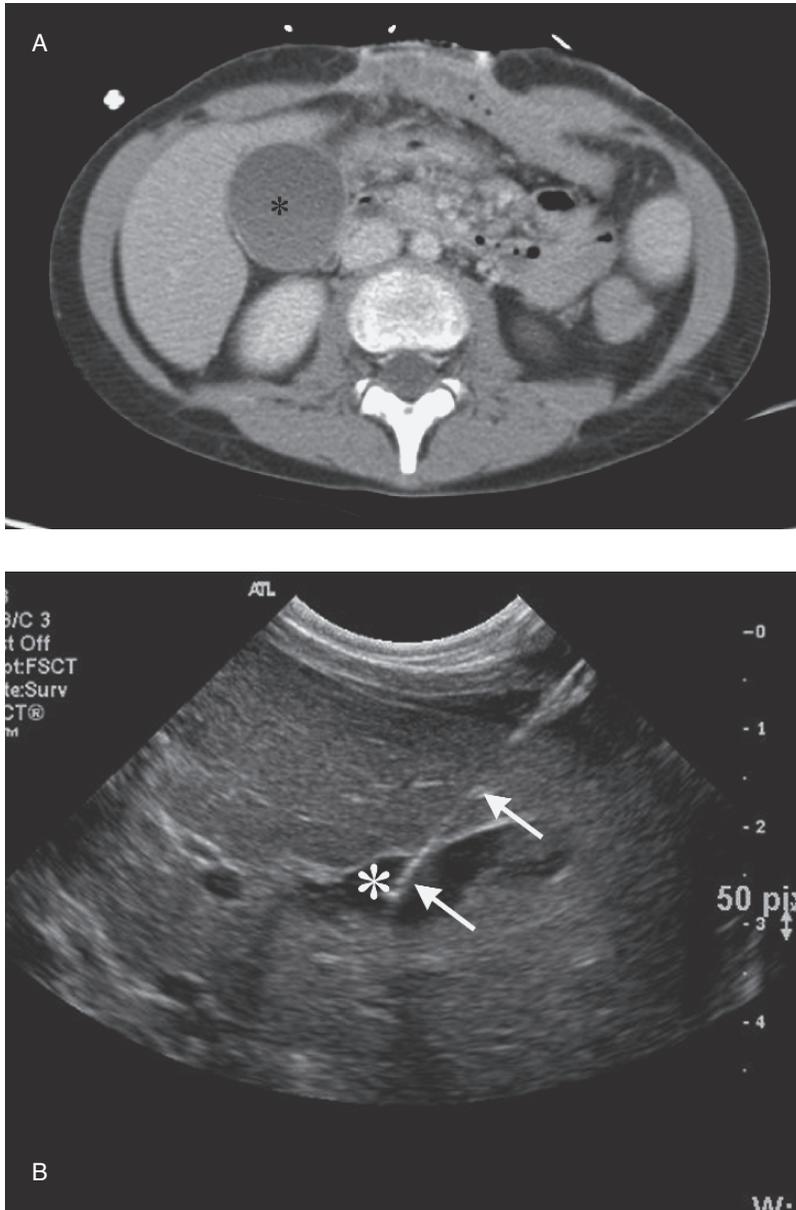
(A) CT scan from a septic postoperative patient shows a distended gallbladder (*). (B) Ultrasound guided needle (arrows) placement into the gallbladder (*). (C) Injection of the drainage tube confirming placement in the gallbladder (*).
